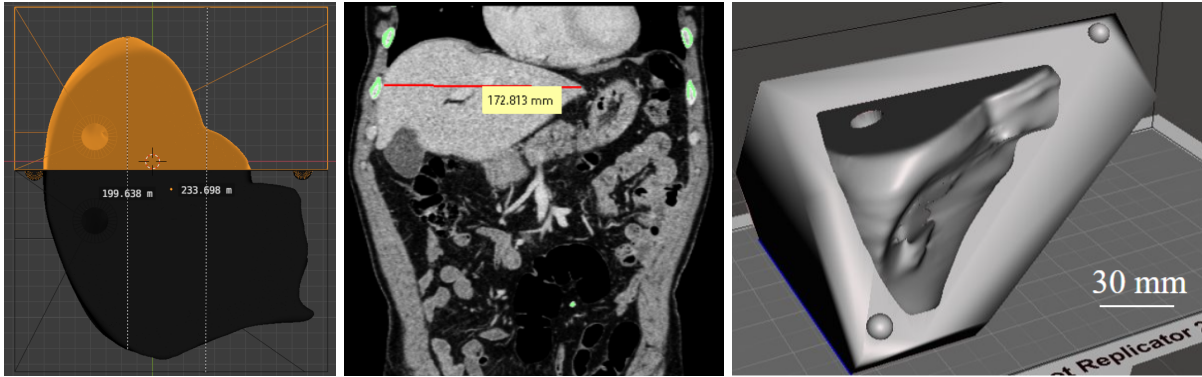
Image of the liver mold in Blender (left), CT scan in InVesalius 3.1 (middle), and the liver mold in Autodesk Meshmixer (right).
